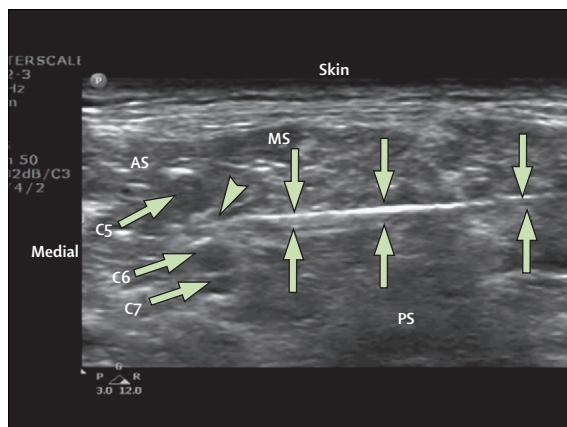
Insertion of a needle into the sheath of the brachial plexus under ultrasound guidance
